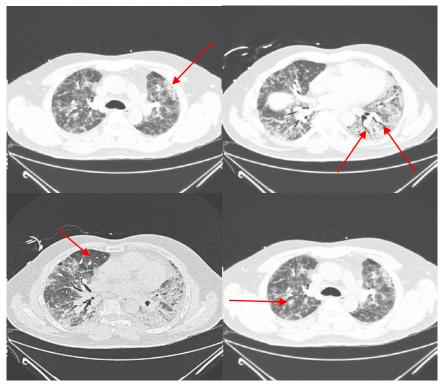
(previous page): Acute on chronic ILD. Features on HRCT that may support an underlying chronic ILD diagnosis in a patient presenting with acute respiratory failure include subpleural reticulations (upper left), traction bronchiectasis (upper right), air trapping (lower left), or peribronchovascular distribution of infiltrate (lower right). This scan is of a patient with underlying chronic hypersensitivity pneumonitis and ongoing exposure to antigen, presenting for the first time with acute hypoxemic respiratory failure.
